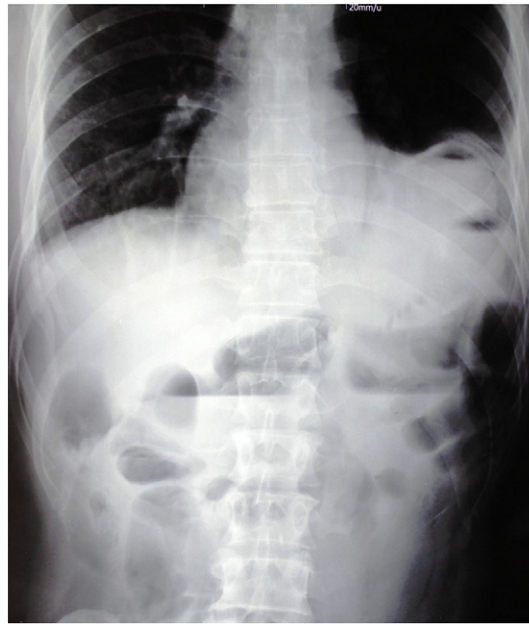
Posteroanterior chest radiography, there are elevated left lung and a gas-filled intestinal loop on the left cardiophrenic angle and abdomen revealed air-fluid levels due to intestinal obstruction.
